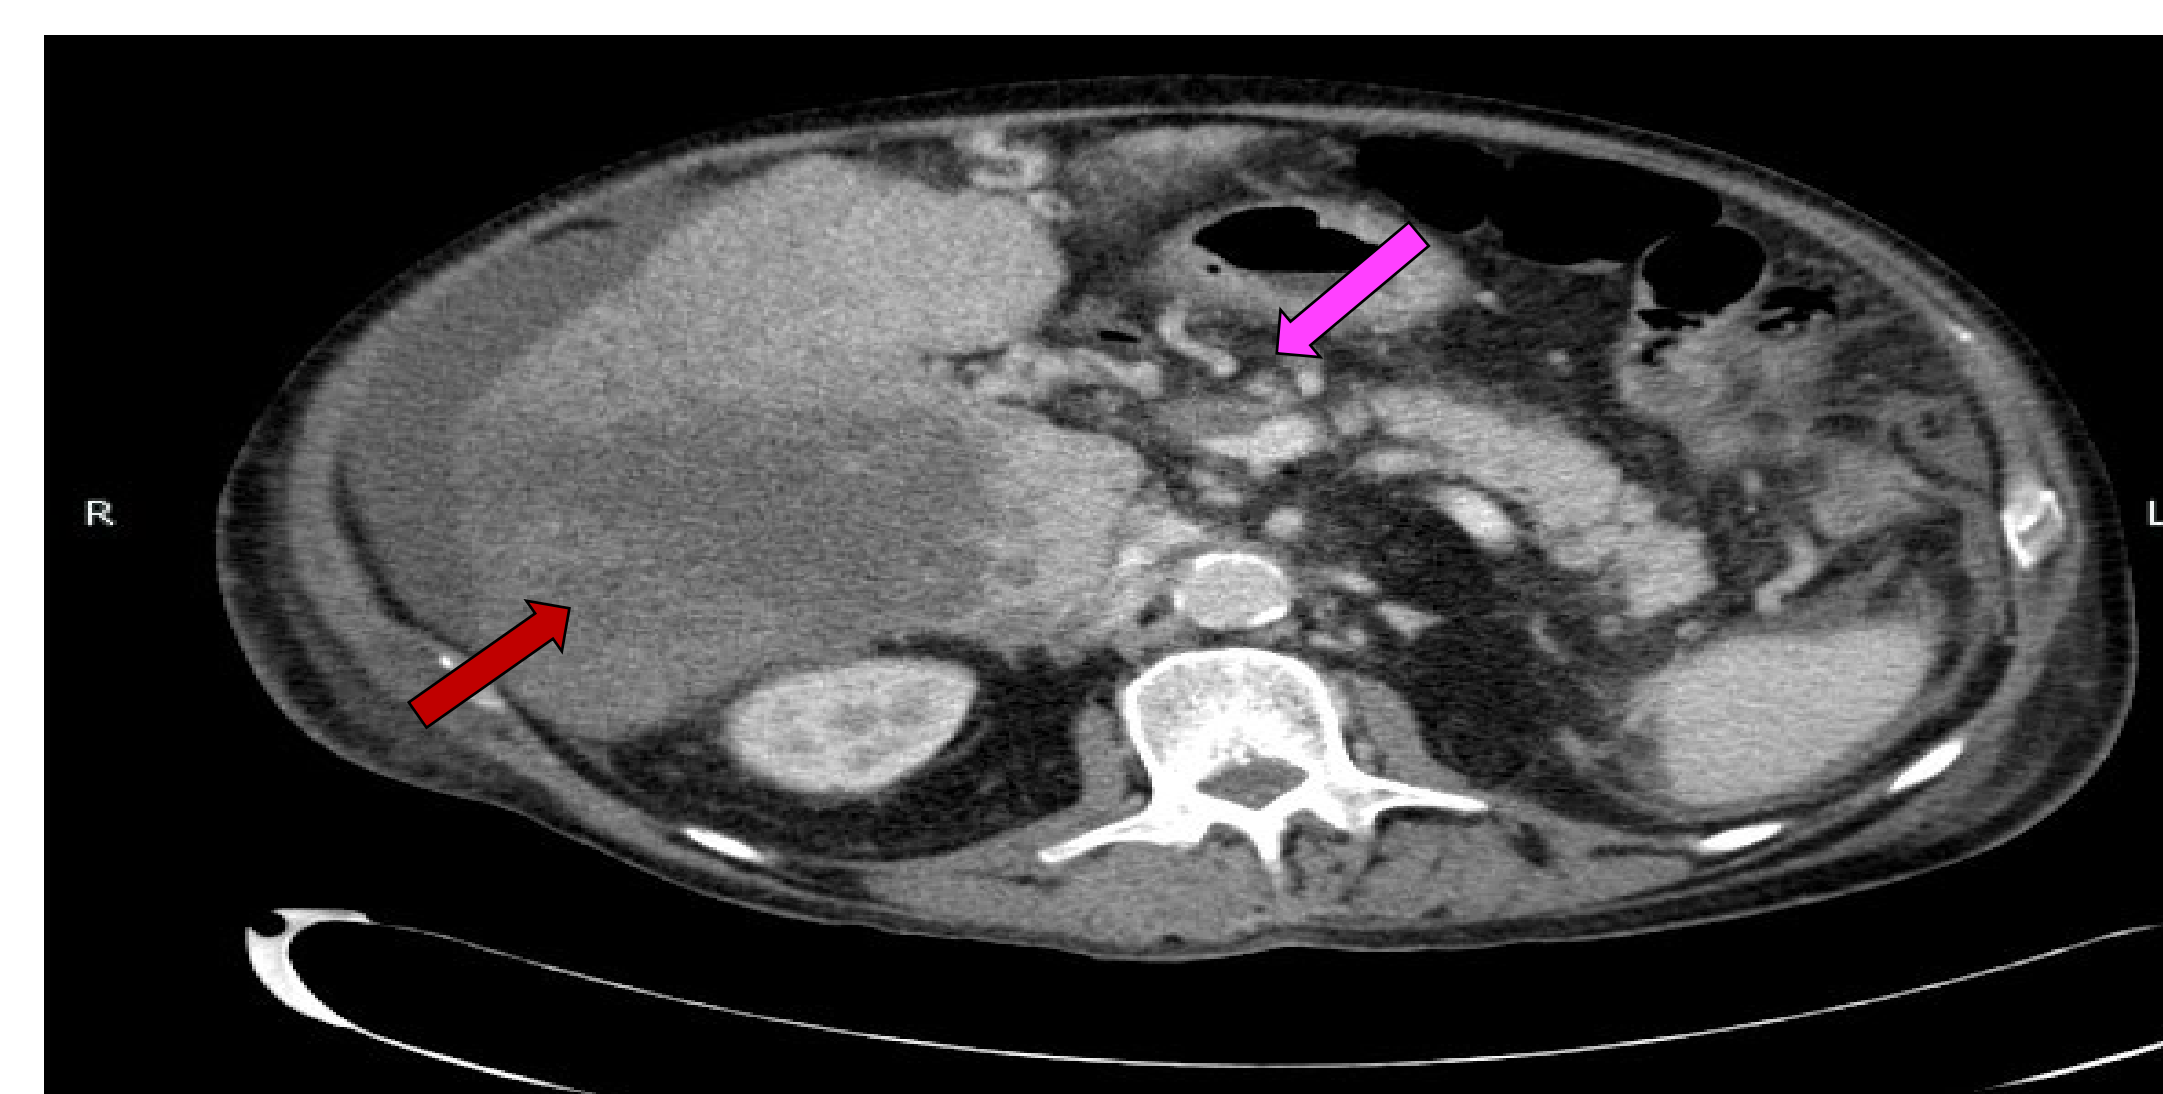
Computerized tomography (CT) scan of the abdomen with contrast showed a large infiltrative heterogeneous mass involving the entire right hepatic lobe with a non-occlusive thrombus extending to the portal vein.
